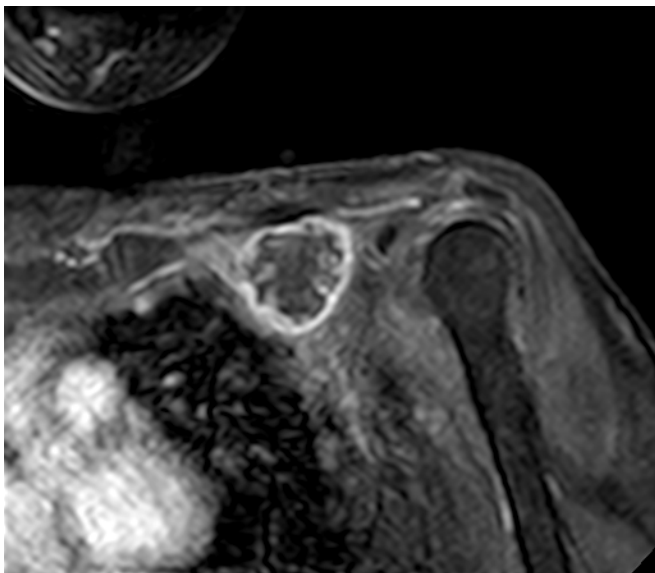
Re-evaluation MRI after neoadjuvant radiotherapy.
